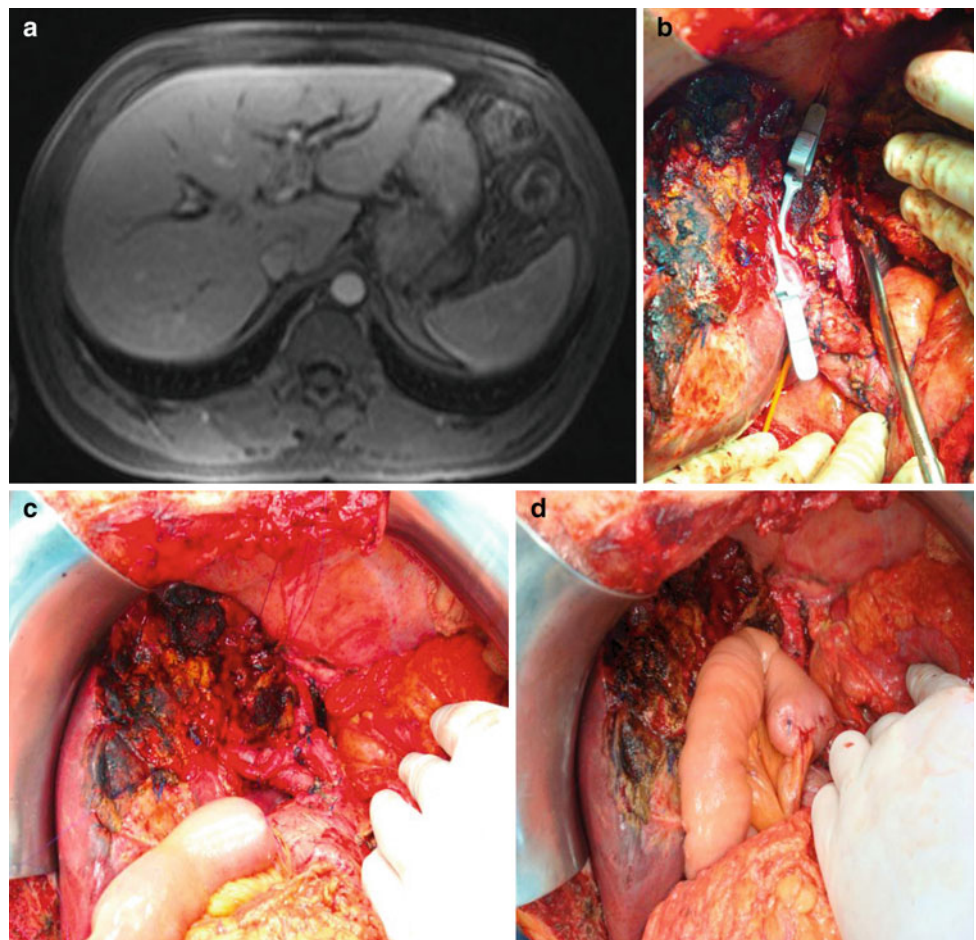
Radiological and intraoperative aspects of gallbladder cancer. a Abdominal CT with a heterogeneous mass in the gallbladder fundus. b–d Radical cholecystectomy with *en bloc* resection of segments IVB and V and hilar lymphadenectomy
